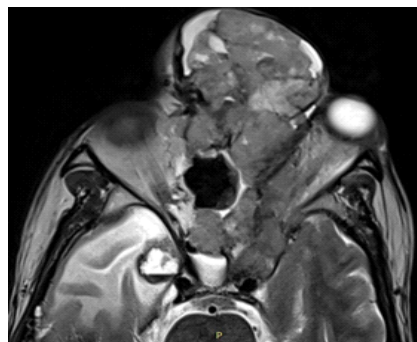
Axial T2 MRI showing extension into the left cavernous sinus and also the right temporal meningeal deposit with resultant anterior temporal lobe parenchymal edema.
